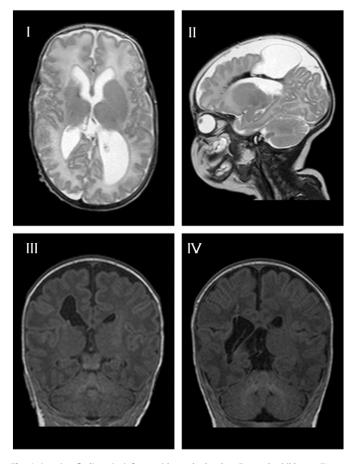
Imaging findings in infants with cerebral palsy: For each child, one T1- or T2-weighted image in the axial, sagittal or coronal plane was chosen for best possible representation of abnormal findings. If not shown, additional abnormalities are described in the legend. I: Axial T2 weighted image of infant with bilateral CP (GMCFS I) showing abnormal deep grey matter (unilateral atrophy in the striatum and thalamus). This infant also had a global bilateral white matter reduction and a marked enlargement of the lateral ventricles. The myelination was delayed but no asymmetry was noted in the PLIC. No cysts were seen, and cerebellum and corpus callosum were normal. II: Sagittal T2 weighted image of infant with bilateral CP (GMCFS IV) showing a large parietal cyst affecting both surrounding white matter and the cortical grey matter. This infant also had multiple smaller cysts and gliosis bilaterally in the parieto-occipital regions, and marked enlargement of the lateral ventricles and of the subarachnoidal space. Global thinning was noted of the corpus callosum, and the myelination was delayed but no asymmetry was noted in the PLIC. The deep grey matter and cerebellum were normal. III: Coronal T1 weighted image of infant with unilateral CP (GMCFS I) showing a parietal cyst accompanied by white matter reduction and dilatation of the lateral ventricle on the same side. Abnormal myelination was noted unilaterally in the PLIC, whereas the cerebellum and grey matter was normal. IV: Coronal T1 weighted image of infant with unilateral CP (GMCFS I) showing a periventricular cyst accompanied by white matter reduction, abnormal deep grey matter and dilatation of the lateral ventricle on the same side. Abnormal myelination was noted unilaterally in the PLIC, whereas the cerebellum and corpus callosum were normal.
